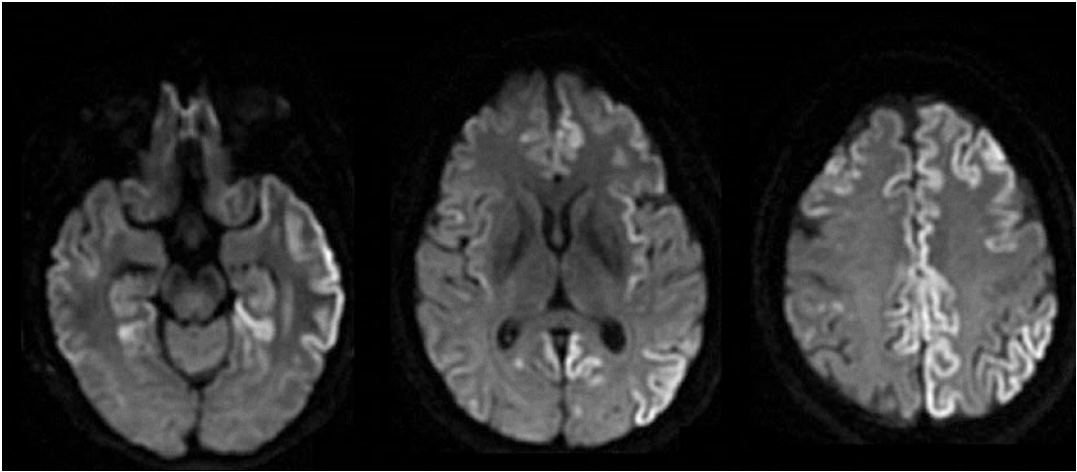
DWI images show multifocal regions of cortical hyperintensities in a patient with CJD. Other CJD patients may have a striatal pattern. Both patterns are pathognomonic for CJD
